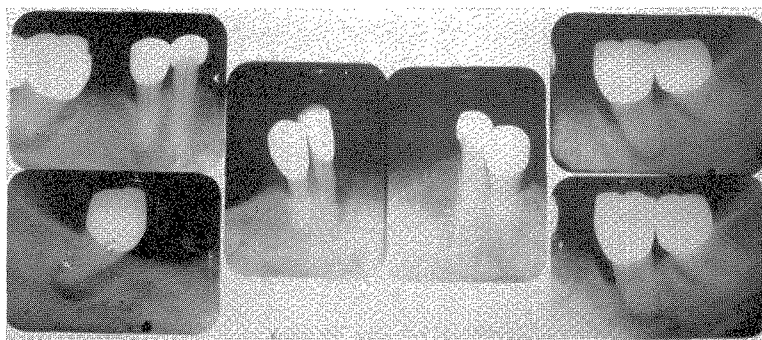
Roentgenograms taken in 1948. This was five years after completion. The molars were removed shortly after, and the lower prosthesis was added to.
